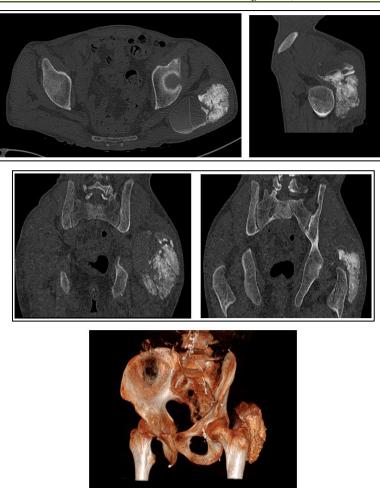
CT scan of the left hip in axial, sagittal and coronal planes, and in 3D reconstruction showing a 125 mm long pseudotumoral calcinosis mass, partially calcified.
